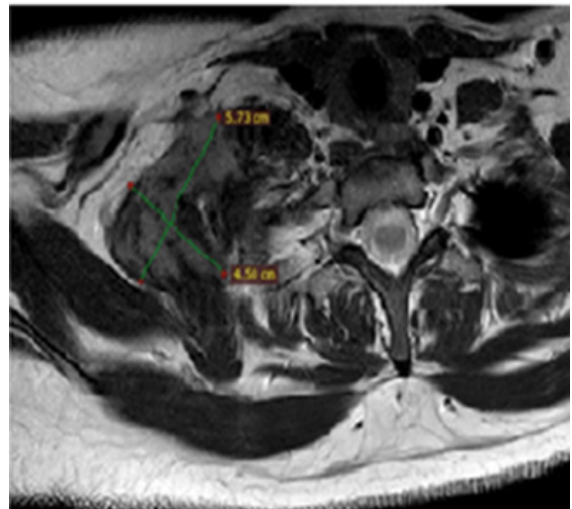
Coronal MRI sequence T2 of the right cervical desmoid tumor
